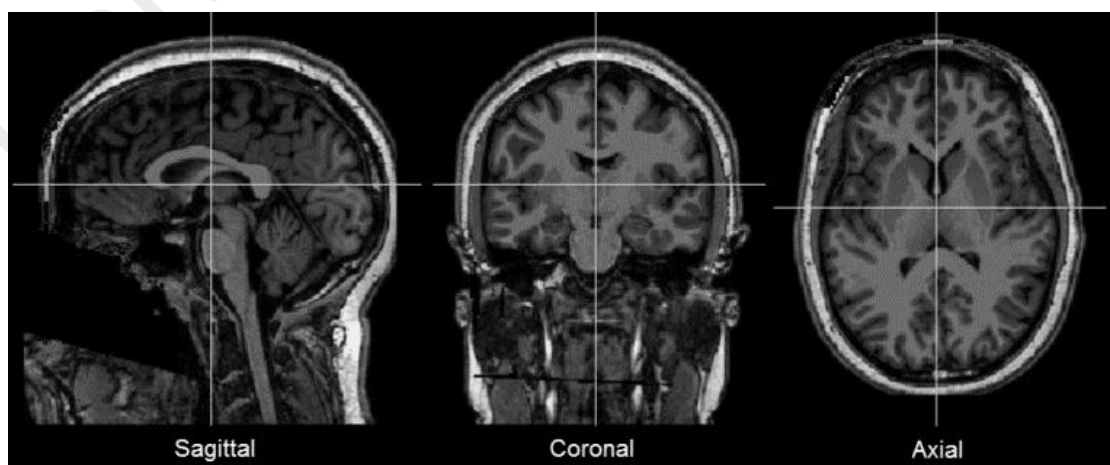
MRI scan of a subject (3rd dataset).
